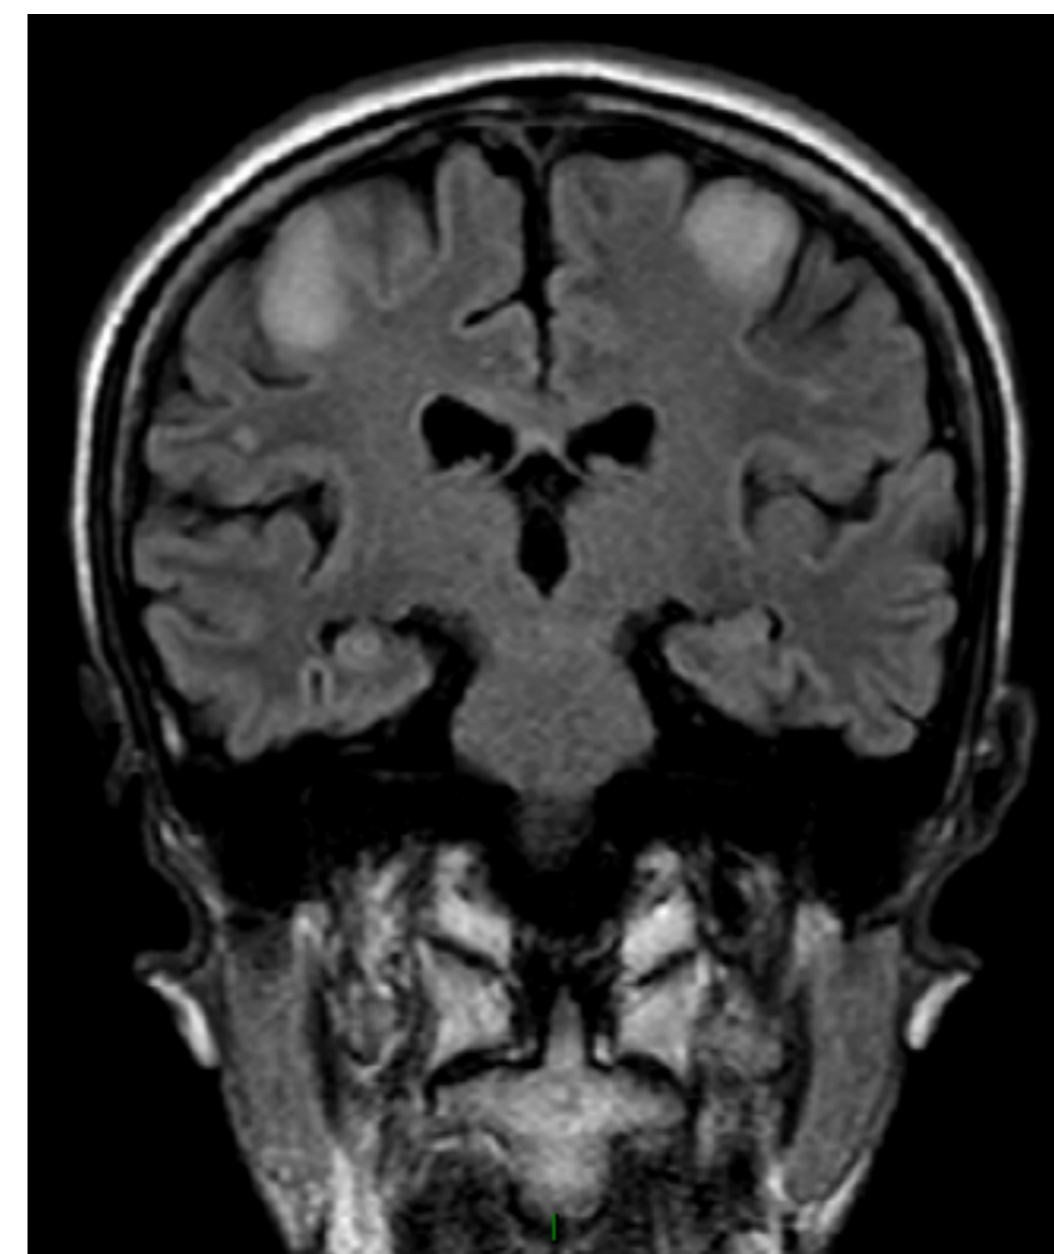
FLAIR coronal and axial images show frontal lesion as hyperintense areas.
